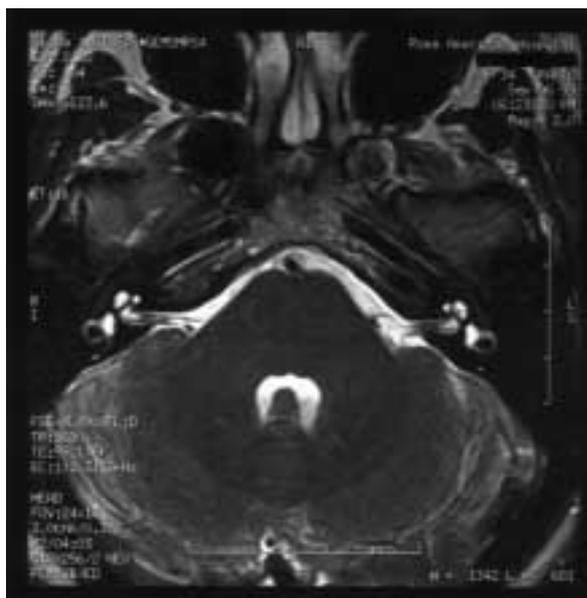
MRI with contrast enhancement. The membranous labyrinth has normal CSF signal. The endolymphatic duct is visualized on the right side, while on the left the endolymphatic duct is not visible and the sac is reduced in volume.
